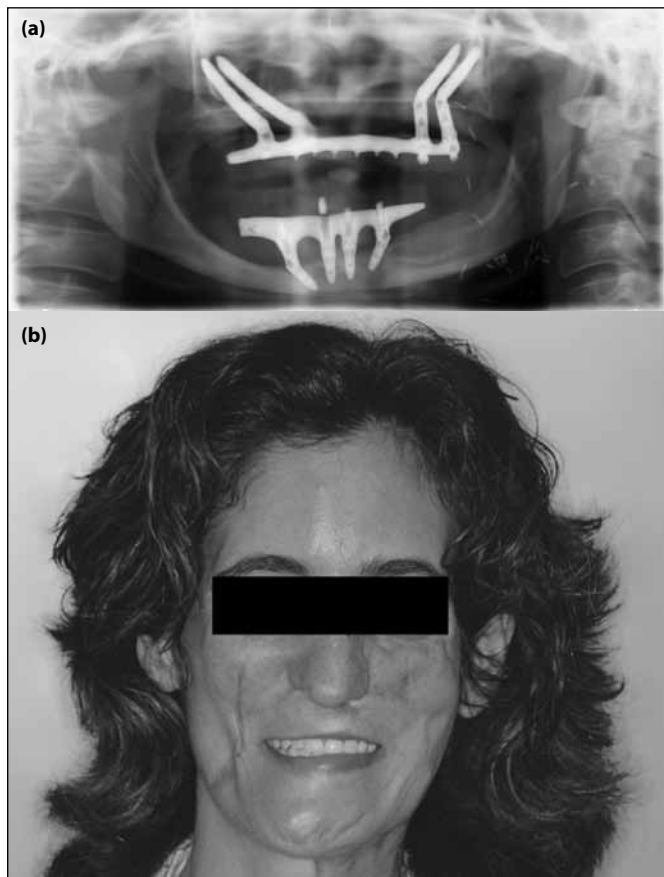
(a) Orthopantomography with 4 years of follow-up. (b) Photograph after 4 years of follow-up with the patient exhibiting the final rehabilitation
